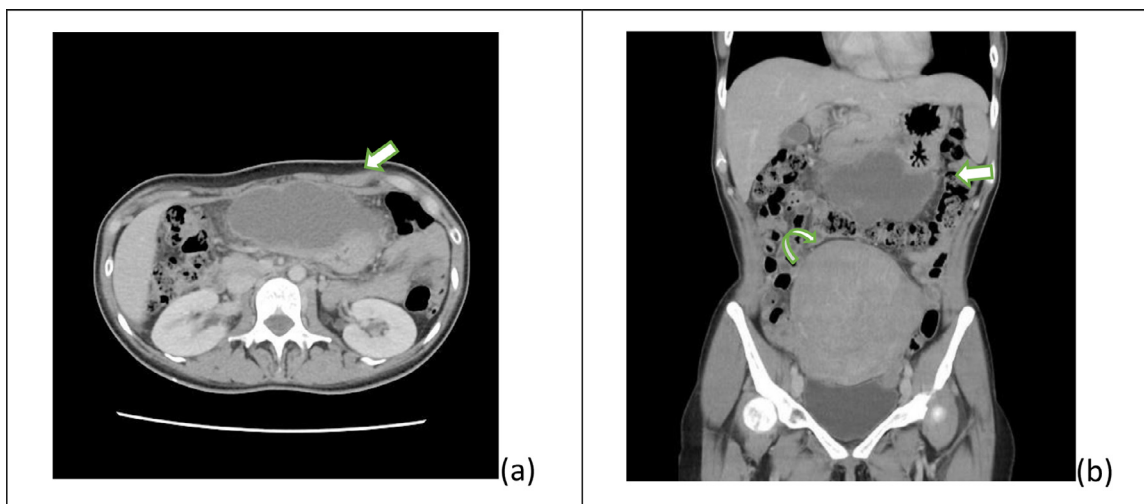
Contrast enhanced abdominal CT, axial view (A) and coronal reconstruction (B), revealed a lobulated thin-walled cystic mass abutting the greater curvature of the gastric body (straight arrows), with mild fatty infiltration of the adjacent omentum. A suspicious uterine myoma in the lower abdomen (curved arrow in B).
